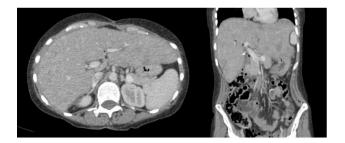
Andominal CT with surgical changes due to hepatojejunostomy without evidence of stenosis, without dilatation of the intrahepatic and extrahepatic biliary tract; pneumobilia due to surgical history.
